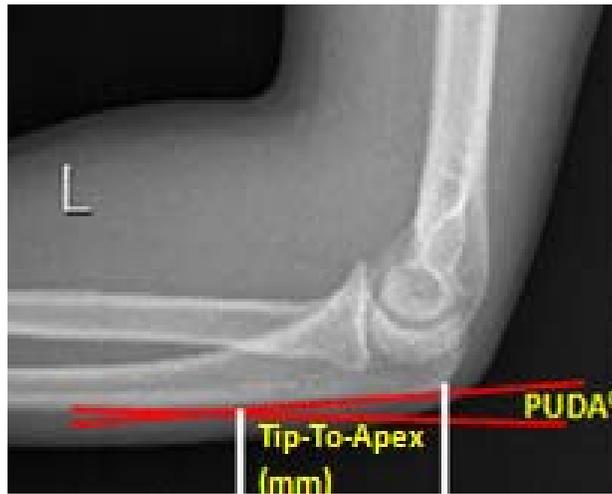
A lateral radiographs of elbow showing location of the apex of the PUDA.
